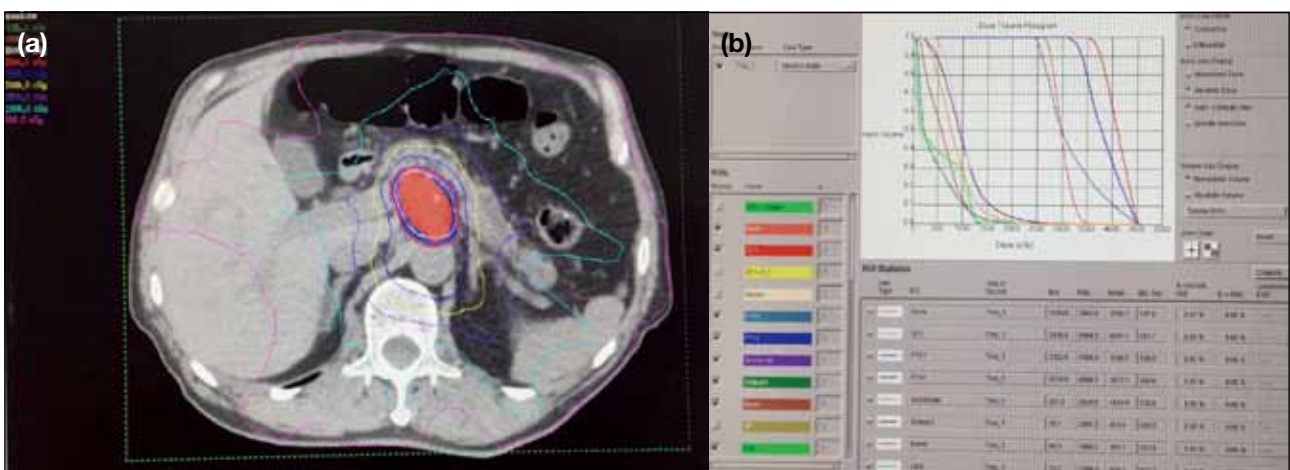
(a) Computed tomography depicts a treatment plan of 33 Gy in 5 fractions for a tumour in the head of the pancreas, and (b) the corresponding dose-volume histogram.
